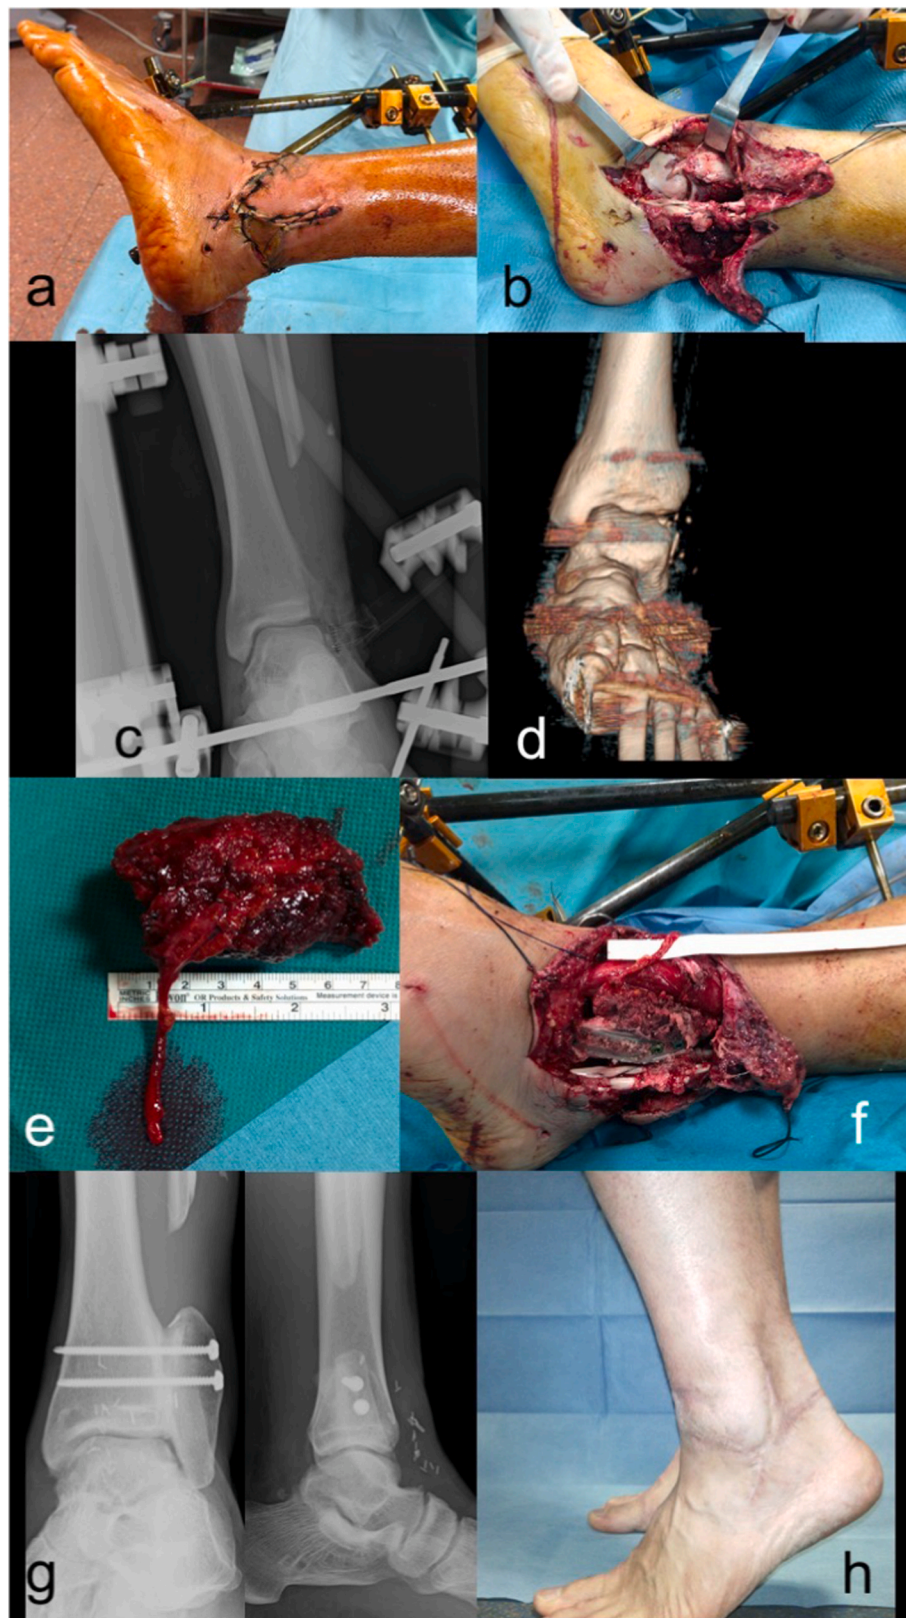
Clinical and radiographical appearance of patient 2. a) Soft tissue condition before debridement b) intraoperative picture of bone defect c and d) pre operative x-ray and CT scan showing lateral malleolus defect e) harvesting of the iliac crest flap with the vascular pedicle clearly visible, f) Positioning of the vascularized bone graft with screw fixation and end-to-end microvascular anastomosis to the anterior tibial artery g) Radiographic and h) clinical appearance 8 years after reconstruction.
